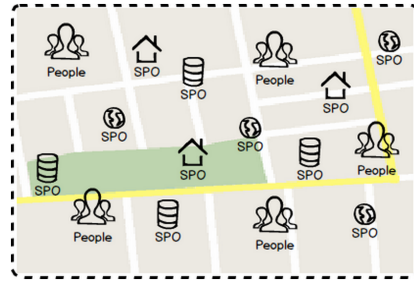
Interaction in PSMA
